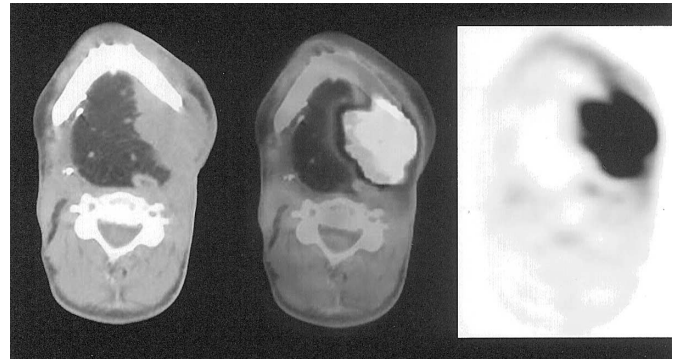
PET/CT showing intense FDG activity in the left submandibular 5 × 3 cm biopsy-proven recurrent squamous cell carcinoma soft tissue mass (SUVmax of 22). Note the important distortion of the normal neck anatomy after radical surgical resection.
